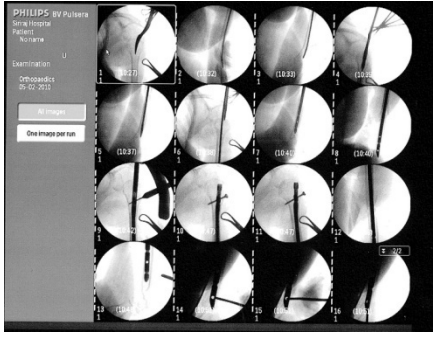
The series of Fluoroscopic X-ray that use in close intramedullary nailing operation.
